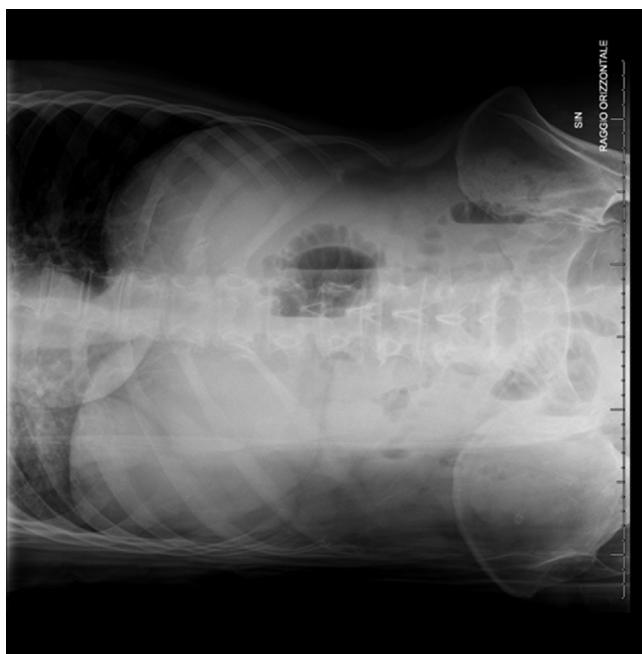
X-ray shows abdominal levels.
